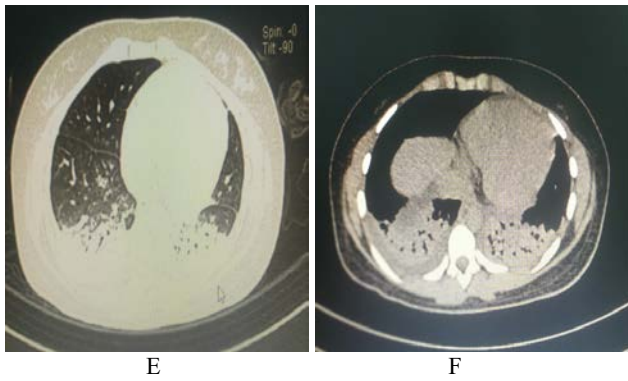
HRCT of chest showing bilateral consolidation with air-bronchogram, bilateral pleural effusion with prominent fissures due to collection of fluid. (E and F).
